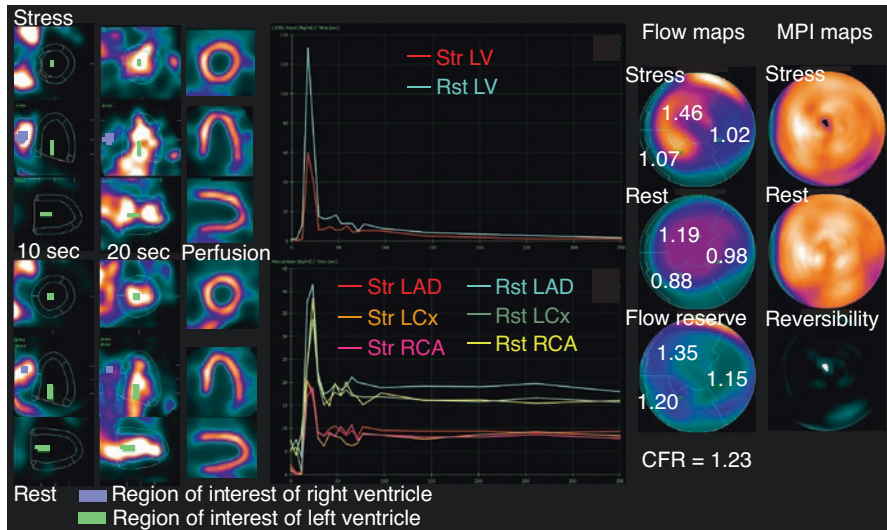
Example of SPECT myocardial blood flow (MBF) information. One-day Tc-99m sestamibi stress-rest protocol (259 MBq for stress and 777 MBq for rest) was used. Stress (Str) and Rest (Rst) flows are computed from early dynamic imaging for each vascular territory, by deriving regional time activity curves for the myocardium and for input blood in the left atrium or left ventricle and applying compartmental models. These values can be used to calculate myocardial flow reserve (MFR) as the ratio between stress and rest MBF. Reduced MFR (<2.0) may be useful to identify the presence of multivessel-disease leading to balanced ischemia. This patient had normal regional myocardial perfusion, but decreased MFR and was ultimately found to have obstructive triple-vessel disease on coronary angiography. (Case provided courtesy of Dr. Alejandro Meretta, Instituto Cardiovascular de Buenos Aires)
